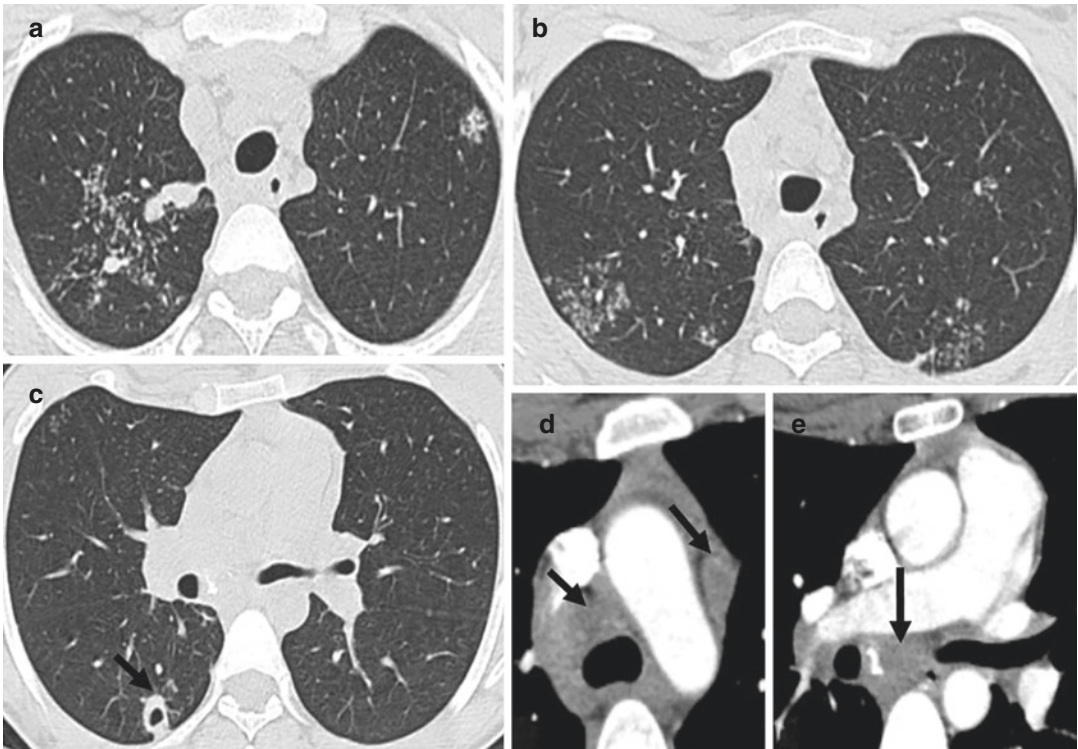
Atypical mycobacteria infection (*Mycobacterium fortuitum*) in a 22-year-old man with no past medical history who presented with dry cough and weight loss. (a–e) Axial contrast-enhanced CT images show tree-in-bud
